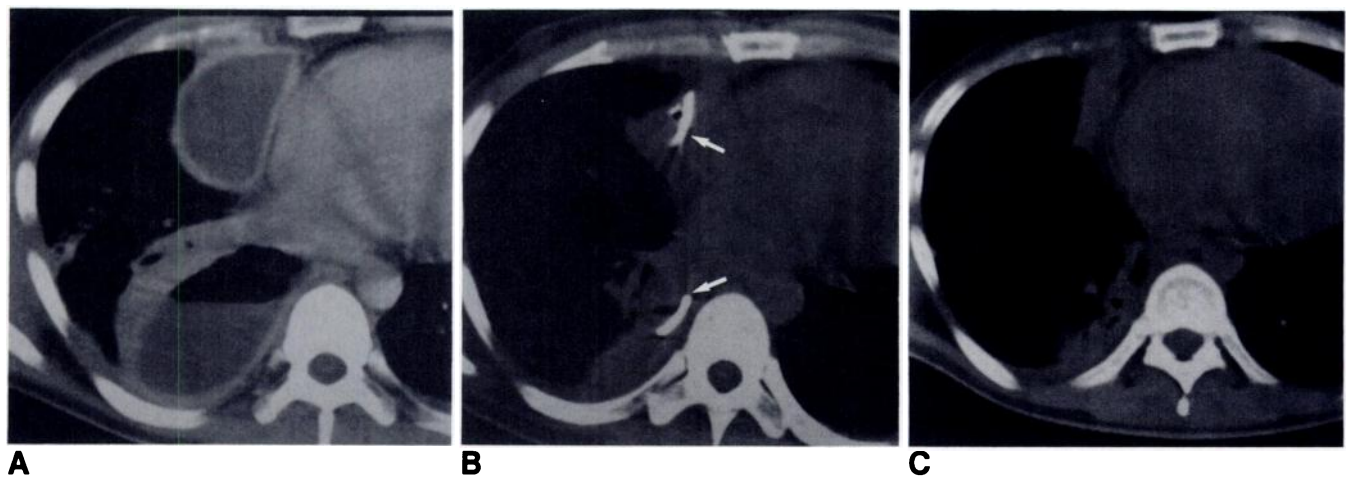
CT scans show successful drainage of bilocular collection.
